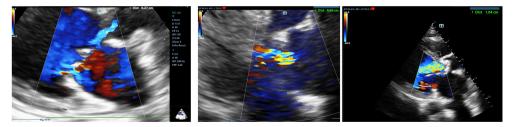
b.16. Different severities of aortic; left: mild AR (vena contracta 0.27 cm, flow jet is not dense and eccentric); middle: moderate AR (vena contracta 0.6 cm); right: severe AR (vena contracta 1.04 cm, intense large flow jet) regurgitation (parasternal long axis view, color Doppler)
